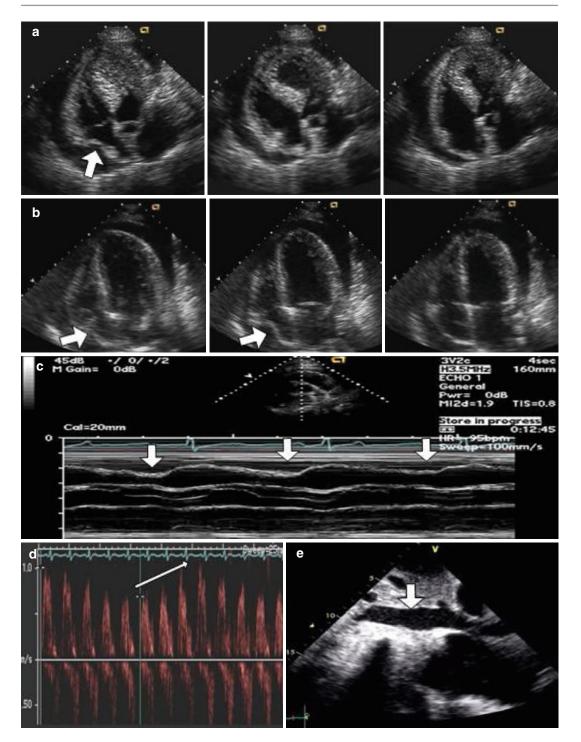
Echocardiographic findings in pericardial tamponade. (a) Transient inward motion of the right atrium (*arrow*) is commonly seen in patients with pericardial effusion and it is not specific for tamponade. (b) A sustained collapse of the right atrium (*arrows*) lasting at least one third of the cardiac cycle is specific for
